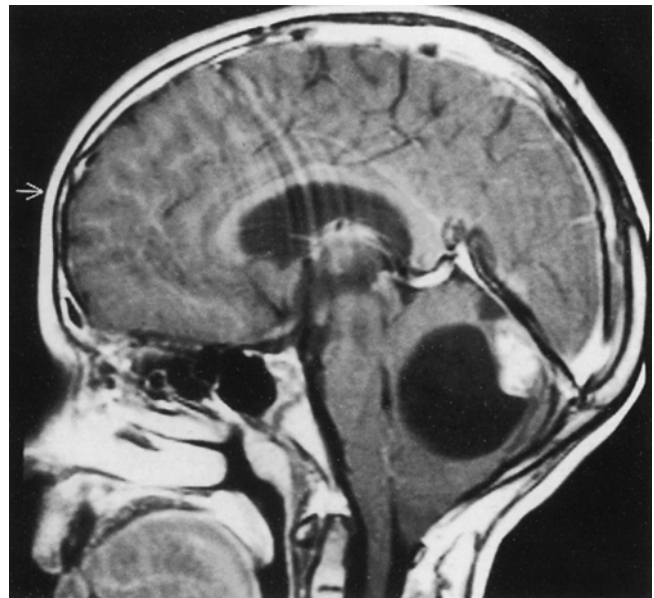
Sagittal T1-weighted MRI with gadolinium showing a large posterior fossa cyst with an enhancing nodule characteristic of a pilocystic astrocytoma. Note that the cerebellar tonsils have herniated through the foramen magnum
